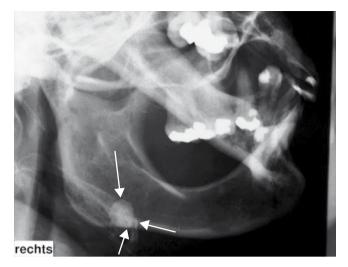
Calculus of the submandibular gland. On the radiograph the oblique lateral view of a well-circumscribed homogeneous increased projection zone in the mandible (*arrows*). This finding corresponds to a calculus in the submandibular gland
